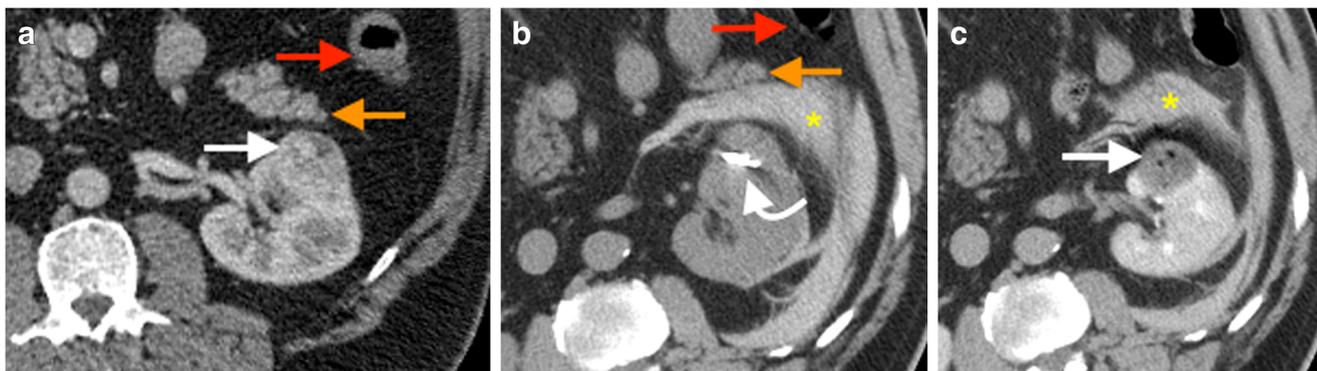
Axial enhanced CT (a) of a 65-year-old man with a 3.4-cm cT1a endophytic clear cell RCC arising from the anterior left mid kidney (white arrow). RENAL score: 6a. The pancreas (orange arrow) closely approximates the tumor and the colon (red arrow) is in proximity to the tumor. Axial unenhanced CT (b) with the patient in an oblique position after placement of 2 microwave antennas (curved arrow) and hydrodissection (asterisk). The pancreas was displaced approximately 2 cm by faintly
